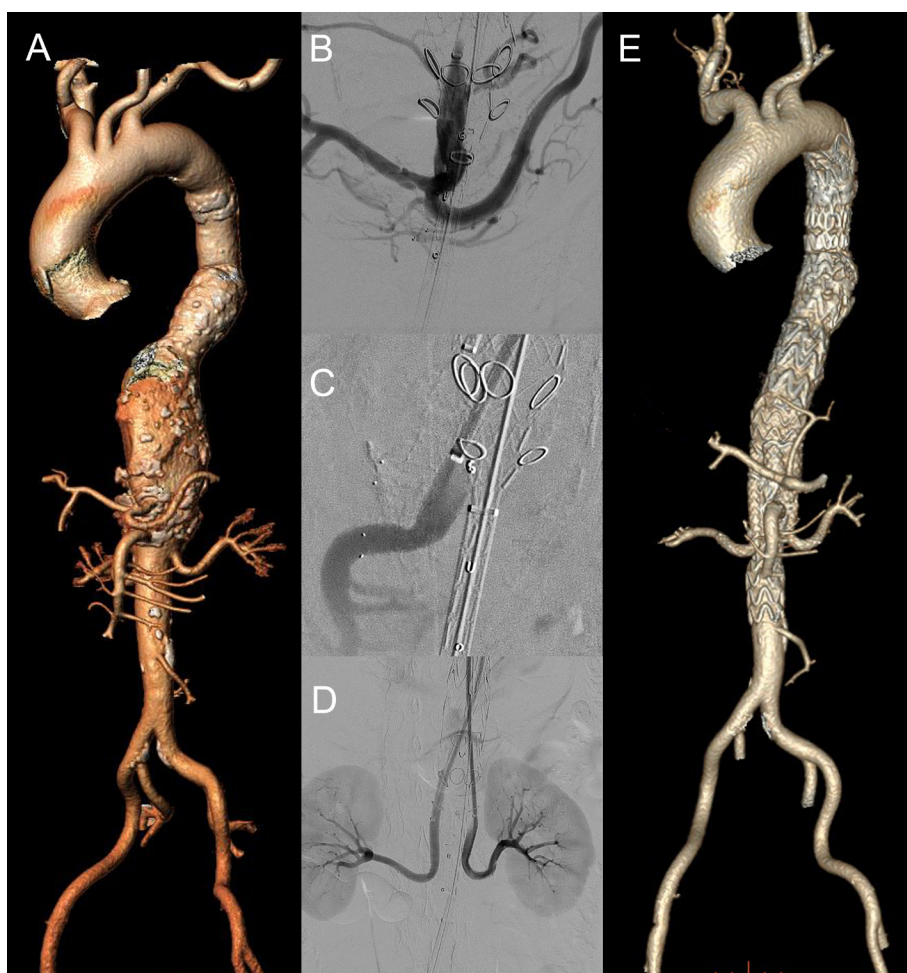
Clinical case of a man aged 58 years with extent type V thoracoabdominal aortic aneurysm. (A) Preoperative CT angiography (CTA) three-dimensional reconstruction showing that the aneurysm involves the splanchnic vessels and extends down to renal arteries. (B, C and D) Intraoperative selective angiography demonstrating patent renovisceral arteries. (E) Postoperative CTA indicating a successful exclusion of the aneurysm, with no evidence of endoleaks, stenosis or occlusion of bridging stent grafts.
